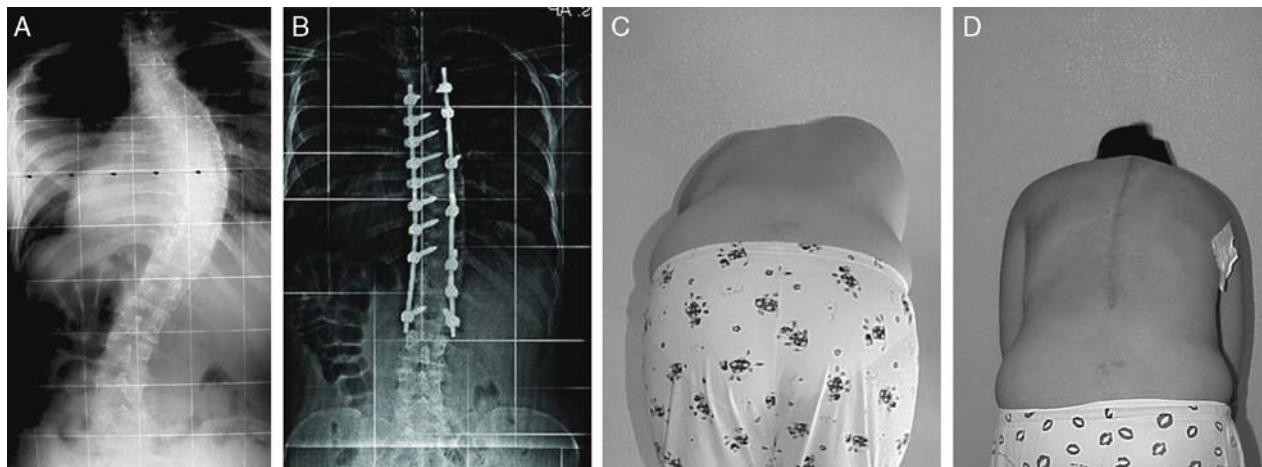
A 14 years old female with a Lenke 2AN curve, operated on by means of a T4-L1 pedicle screws posterior spinal fusion plus thoracoplasty (T6-T9). Clinical and radiographic results at 5.5 years from the index procedure.
